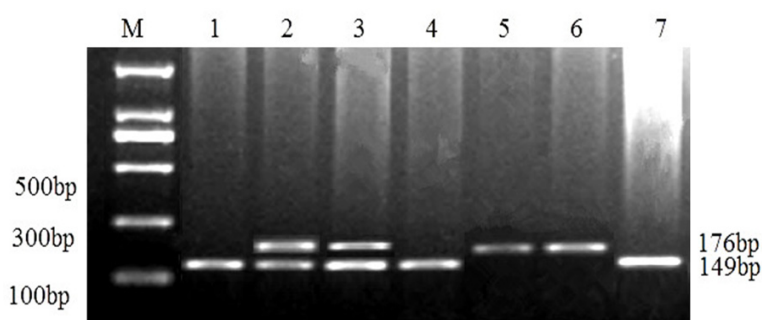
Agarose gel electrophoresis images for *TCF7L2* rs7903146. 5-6 lanes: TT genotype; 1,4 and 7 lanes: CC genotype; 2 and 3 lanes: CT genotype.
